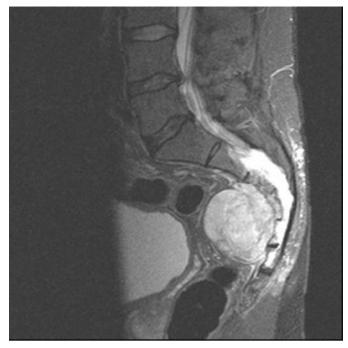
T2 sagittal MRI showing a lesion on the anterior surface of the sacrum which appears destructive with a wide zone of transition
